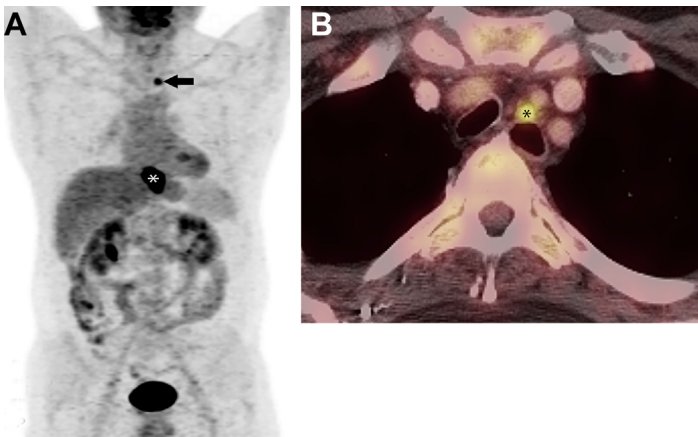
(A) Coronal WB-FDG PET shows increased FDG uptake within the distal esophagus (asterisk) consistent with esophageal cancer and a smaller focus of increased FDG uptake more cephalad in the mediastinum (arrow). (B) Fused axial FDG PET/CT shows increased FDG uptake in a mediastinal lymph node (asterisk) adjacent to the esophagus suspicious for lymph node disease. cN1 was confirmed by EUS-FNA biopsy.
